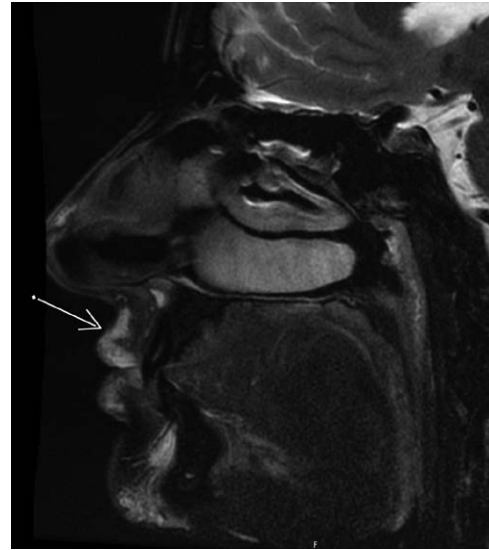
A sagittal T2-weighted fat saturation 3-T magnetic resonance imaging scan obtained using a GE Pioneer magnetic resonance imaging scanner. *Arrow* indicates the hyaluronic acid signal overlying the orbicularis oris.
